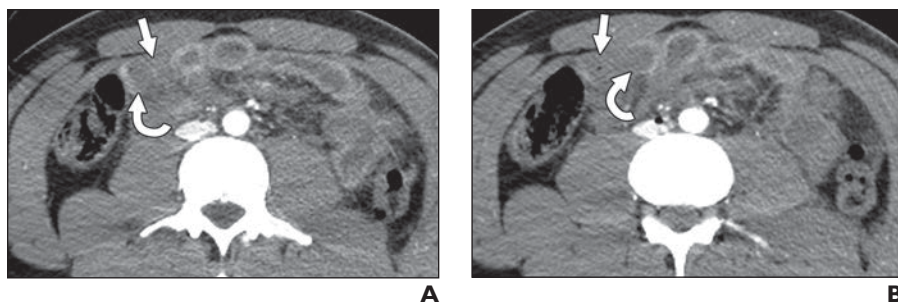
24-year-old man with abdominal injury after motor vehicle collision. A and B, Axial arterial phase CT images show segmental hypoenhancement of ileum (arrow) and sharp demarcation with enhancing wall (curved arrow).
